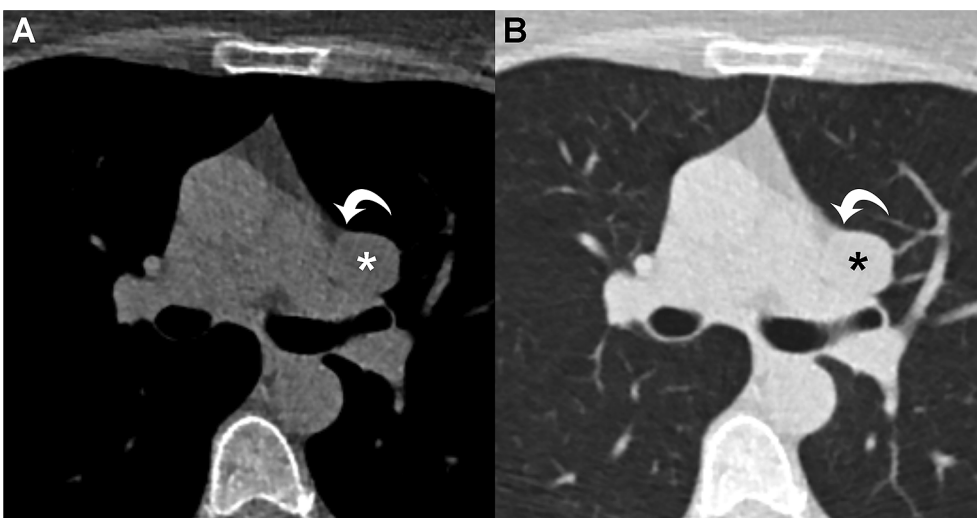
Axial ultra-low-dose CT images with mediastinal window (A) and lung window (B) reveal a round and smoothly margined low-attenuation nodule located anterior to the left hilum (asterisks). The obtuse angle formed between the nodule and the adjacent lung parenchyma (arrows) suggests a mediastinal lesion.
